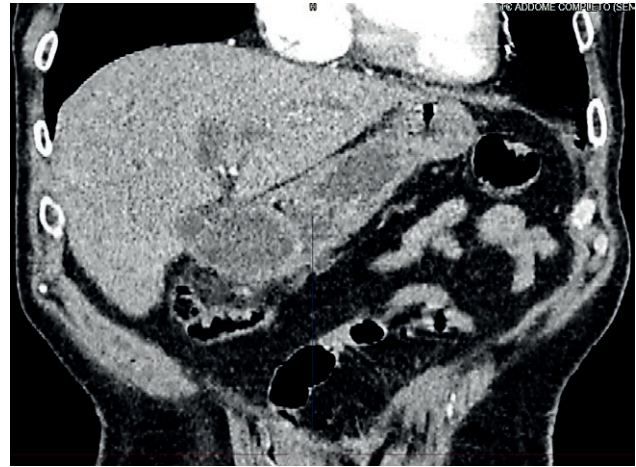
Coronal CT scan of the abdomen showing a tumor at the distal stomach with hypodense core, which was interpreted as suspect GIST.
